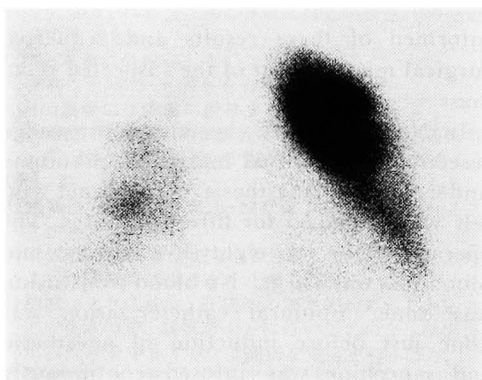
Lung scintigram using  $^{99m}\text{Tc}$  demonstrated lack of perfusion in whole right and lower left lungs.
